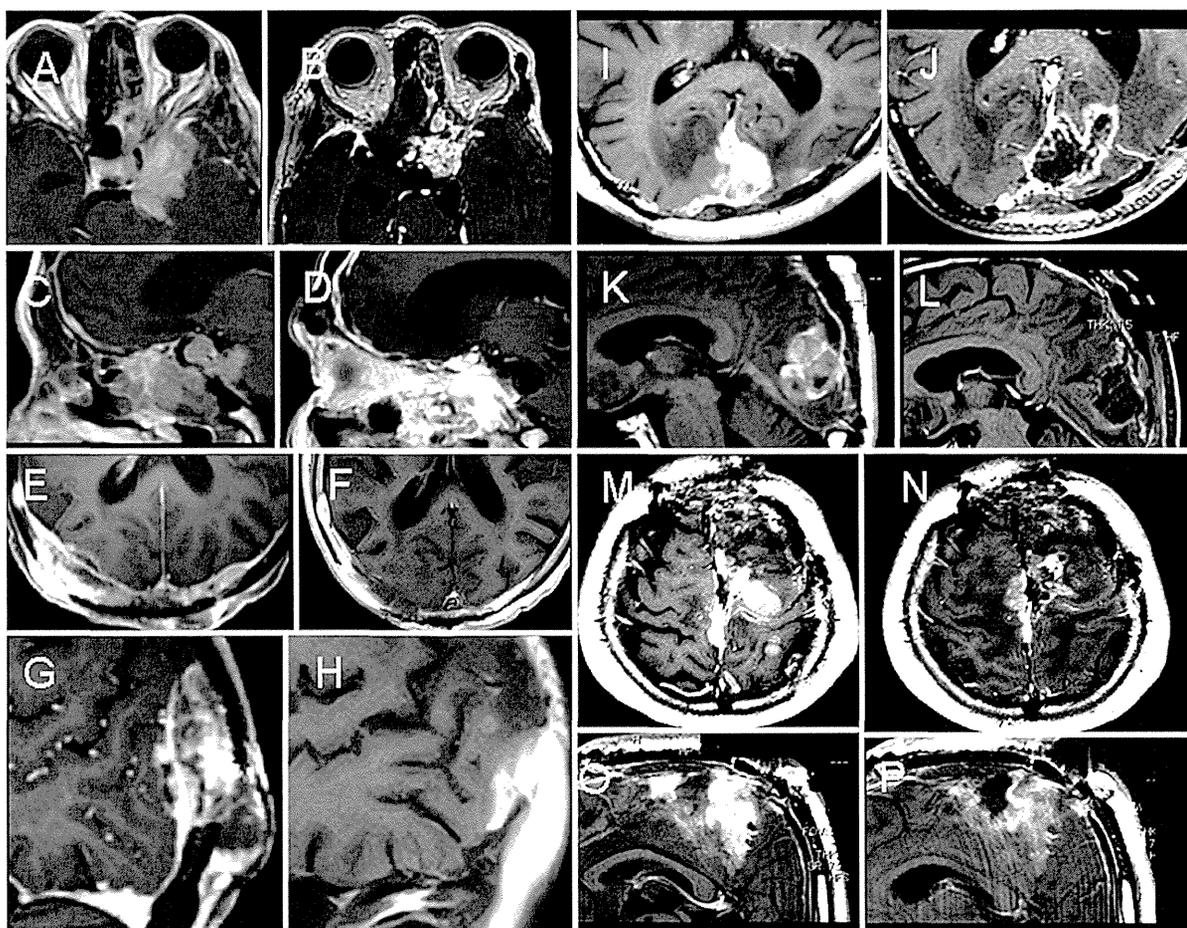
Representative tumor shrinkage after BNCT demonstrated on axial (A, B, E, F, I, J, M and N) and sagittal (C, D, G, H, K, L, O, and P) Gd-enhanced MR images. Each case shows marked tumor volume reduction after BNCT. A–D: Case 17. Images of an anaplastic meningioma before (A and C) and 10 months after BNCT (B and D). E–H: Case 14. Images of an atypical meningioma before (E and G) and 6 months after BNCT (F and H). I–L: Case 18. Images of an anaplastic meningioma before (I and K) and 10 months after BNCT (J and L). M–P: Case 20. Images of an atypical meningioma before (M and O) and 4 months after BNCT (N and P).
